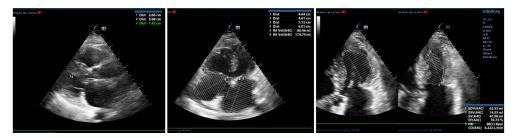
b.5. Nondilated LV with EDD=3.68 cm (left; parasternal long axis), dilated LA (114 ml) (middle; apical 4-chamber 2D) and supranormal LVEF=76% (left; apical 4-chamber view)
